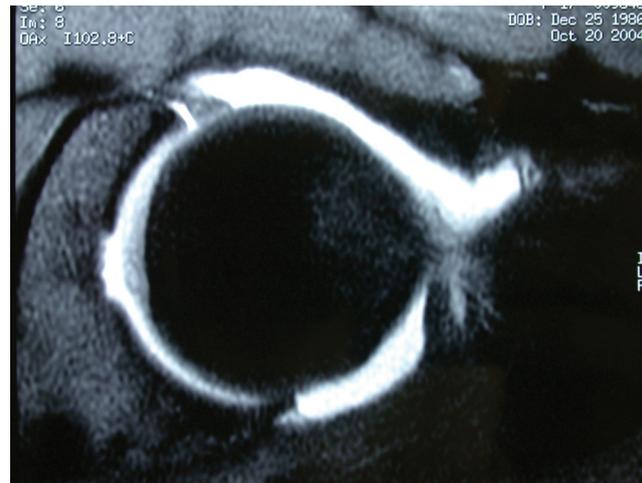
An anterior peripheral labral tear is seen on this T2 axial MRI.
